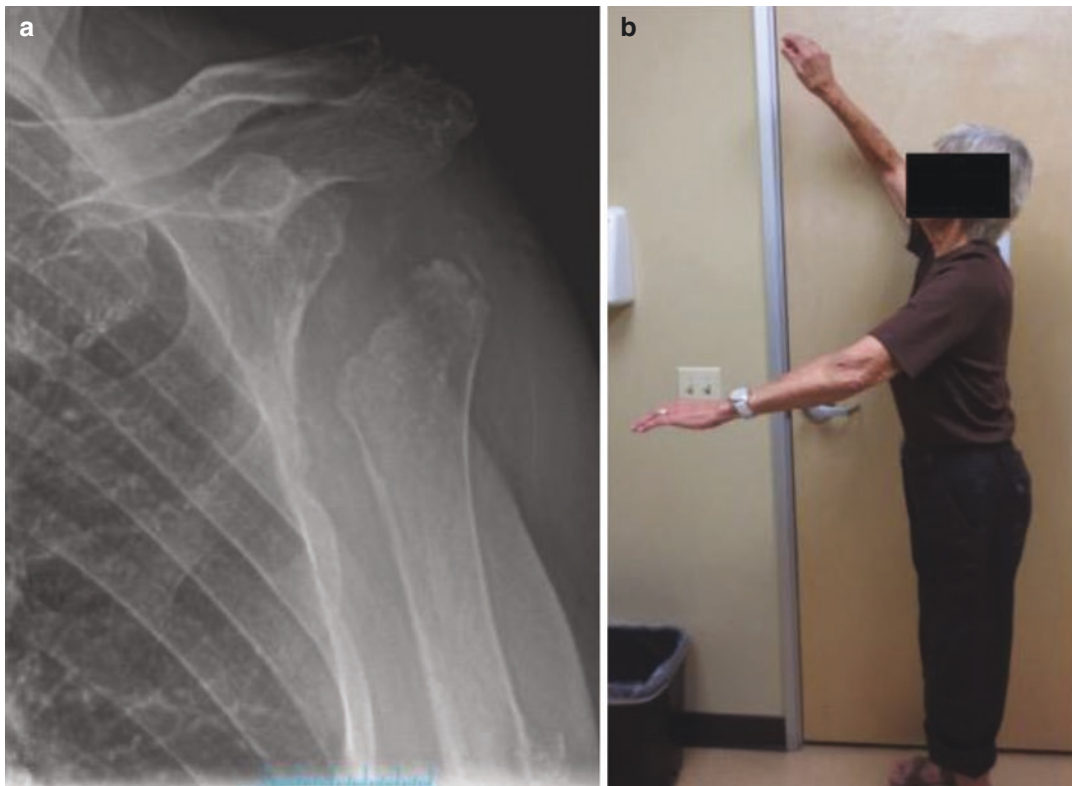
(a) X-ray of the left shoulder of an 82-year-old female after resection of failed reverse shoulder arthroplasty for intractable deep infection and (b) clinical photo
